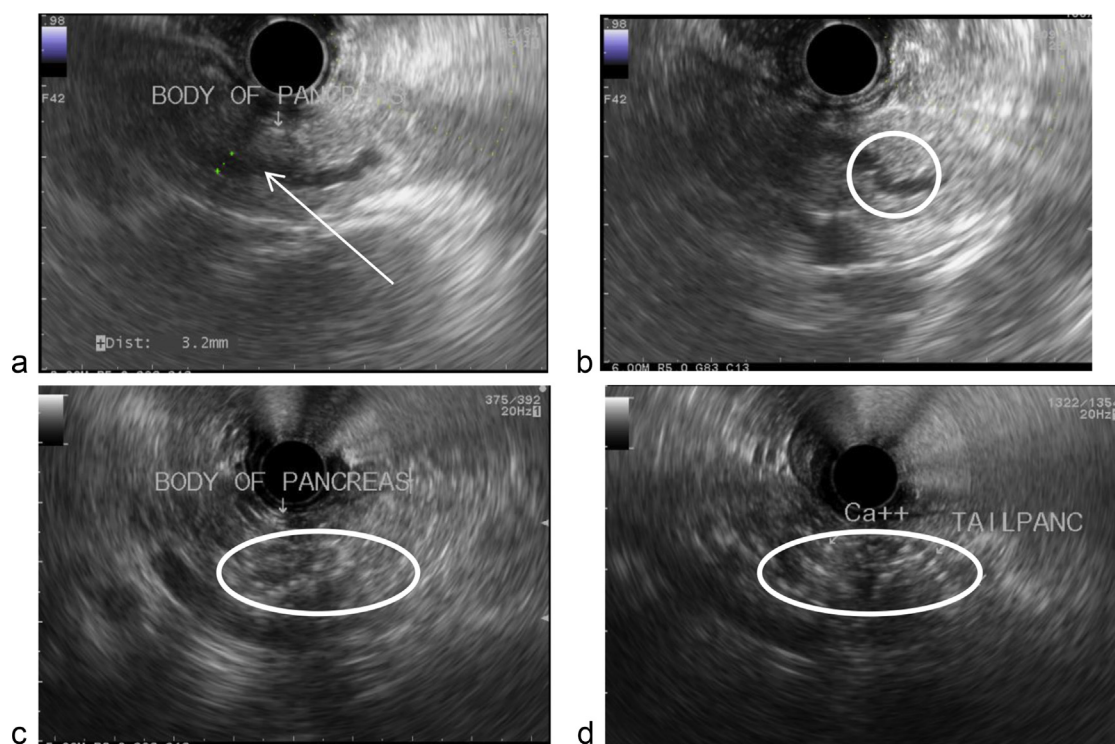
Endoscopic ultrasound findings suggestive of chronic pancreatitis. (A) Main pancreatic duct dilation (arrow). (B) Main pancreatic duct irregularity (circle). (C, D) Hyperechoic foci (calcifications) in the parenchyma of the pancreatic body (C) and tail (D) (circles)
